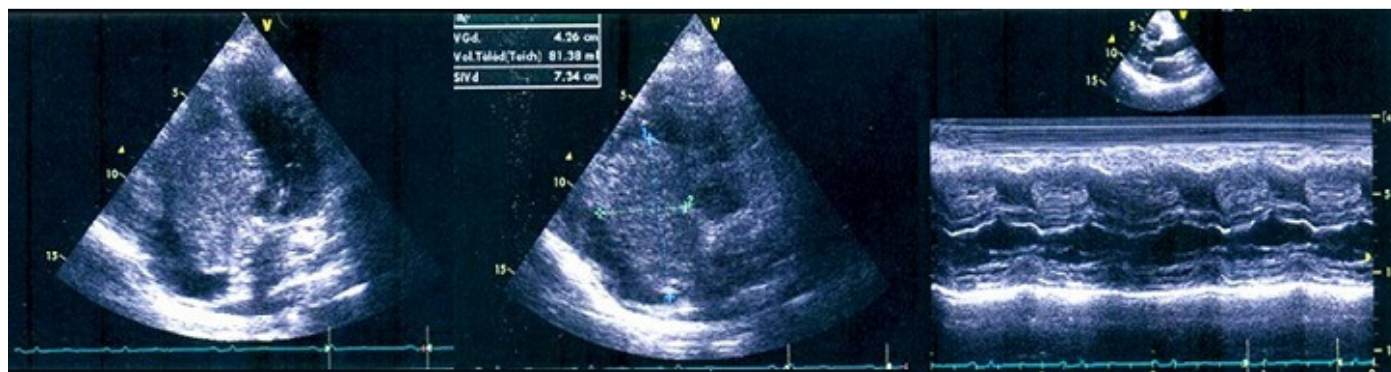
transthoracic echocardiogram: the four chambers and parasternal TM view showing the hyperechoic mass in the right atrium which was wide based and appended to the interatrial septum and prolapsing through the tricuspid valve
